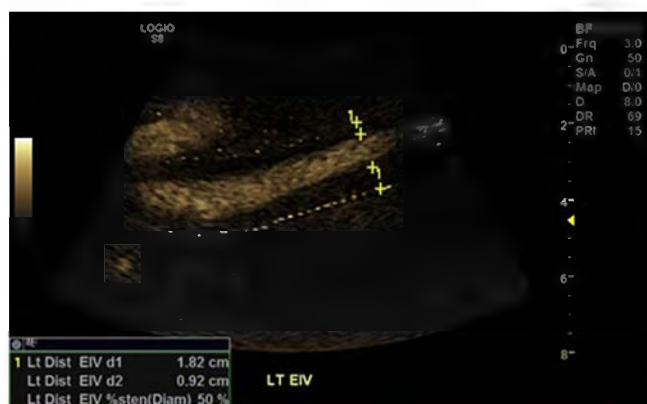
Duplex ultrasound (DUS) B flow mode depicting 50% in-stent restenosis (ISR) in the distal external iliac vein (EIV).
